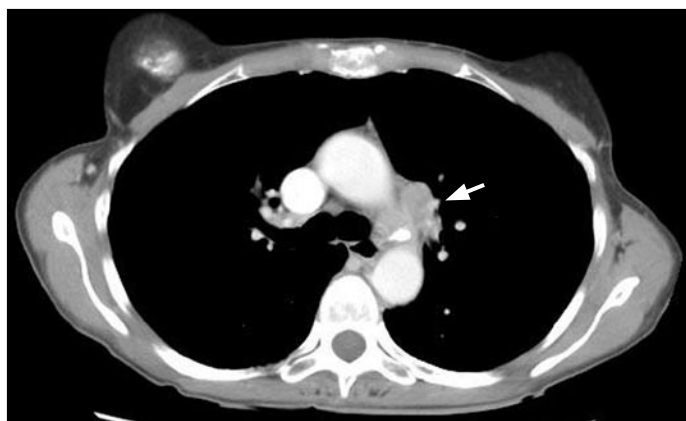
Axial postcontrast CT image demonstrates an enlarged lymph node complex (arrow) in the aorticopulmonary window.
